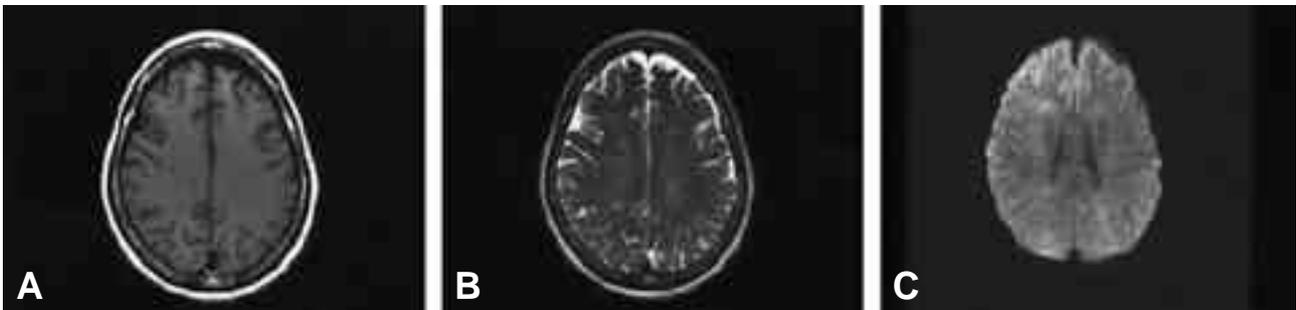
Brain MRI shows diminished these small nodular lesions on day 8 after onset of neurological symptoms. (A) T1-weighted image (B) T2-weighted image (C) Diffusion image.
